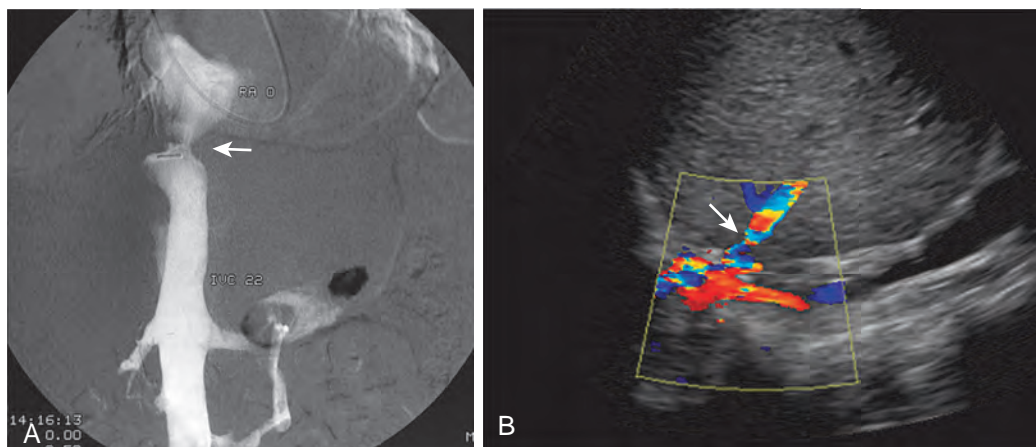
Suprahepatic caval stenosis. A. Color Doppler image shows focal aliasing at piggyback anastomosis. Hepatic venous flow (not shown) was monophasic. B. Venacavography in another patient shows significant narrowing at the suprahepatic caval anastomosis (arrow). This was successfully treated with balloon angioplasty.
